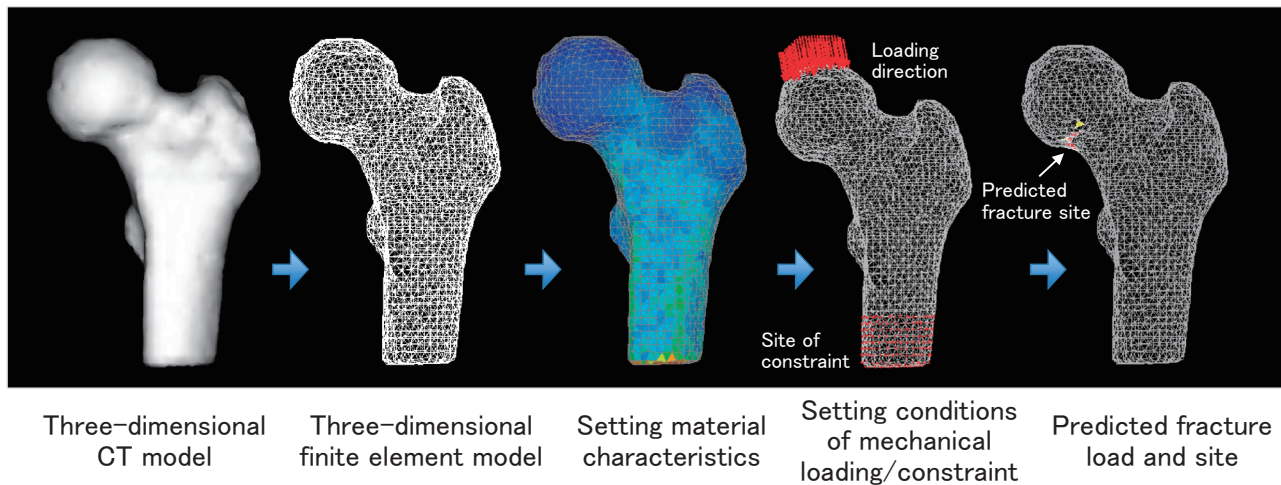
Predicting fracture loading by CT-FEM
